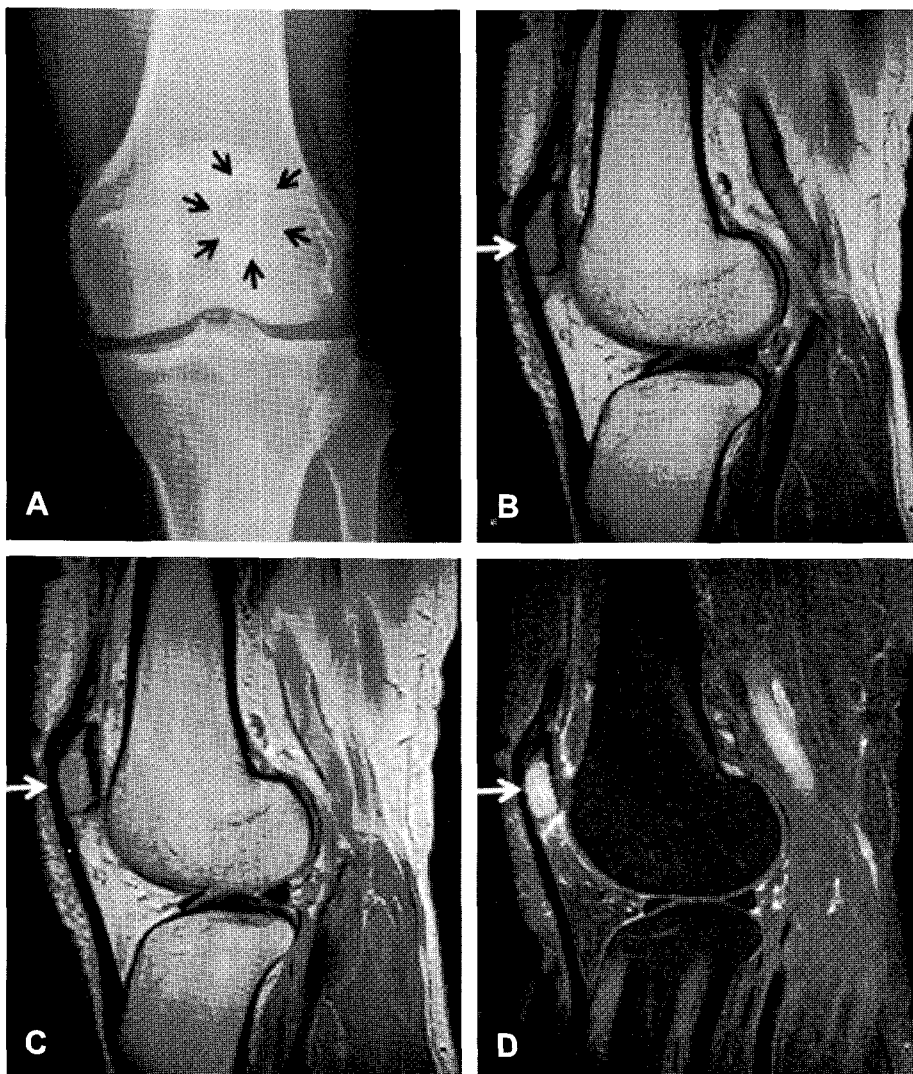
In plain radiograph of left knee (A), there is a 1.4 x 2.2 x 2.4 cm ovoid osteolytic lesion (black arrow) in lateral facet of patella without cortical break or any internal calcifications. Left knee MRI shows an ovoid well-defined mass (white arrow) in the left patella lateral facet. Mass is clearly defined as low signal on T1 weighted image (B), relatively homogeneous increased signal on T2 weighted image (C) with diffuse enhancement after contrast infusion (D). Adjacent patella shows mild enhancement of the marrow and regional soft tissue edema. But no evidence of any cortical destruction is noted.
